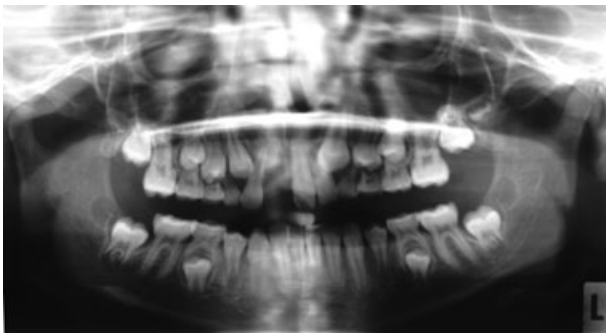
The orthopantomogram shows the loss of tooth 11.
